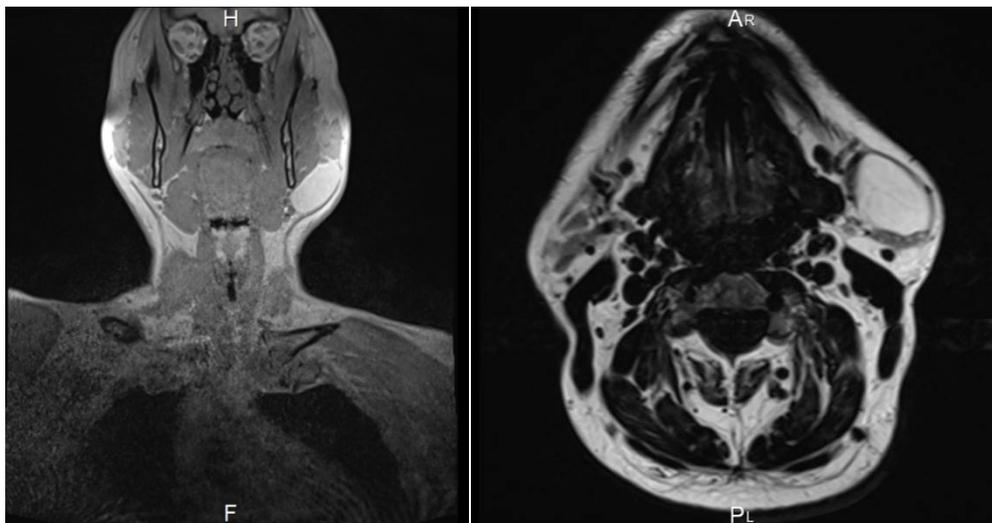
Imaging methods for examination: MRI, showing tumor formation in the left parotid gland
